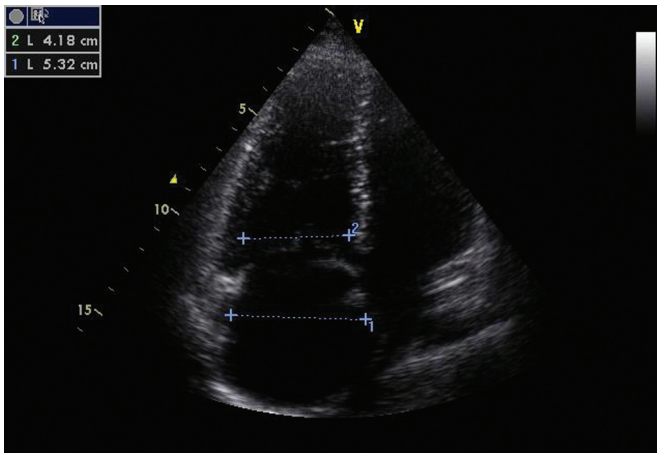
Transthoracic echocardiography shows right atrial and ventricular
